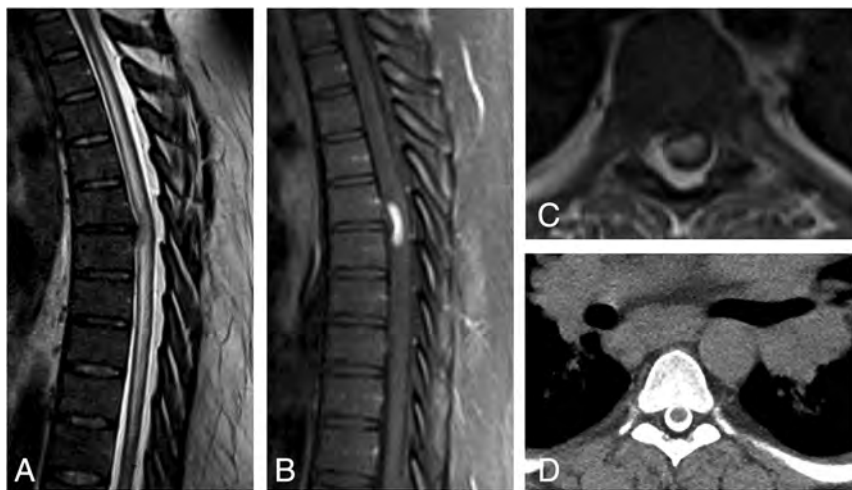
A 35-year-old man with 1 month of progressively worsening lower-extremity weakness, paresthesia, and difficulty with ambulation. Sagittal T2-weighted (A) image shows a disc extrusion at T6–7, with long-segment cord signal abnormality centered at this level. Postcontrast sagittal (B) and axial T1-weighted (C) sequences demonstrate focal cord enhancement at the level of the disc extrusion. CT myelogram (D) performed for further evaluation of the cord abnormality shows marked bilateral hilar adenopathy.
